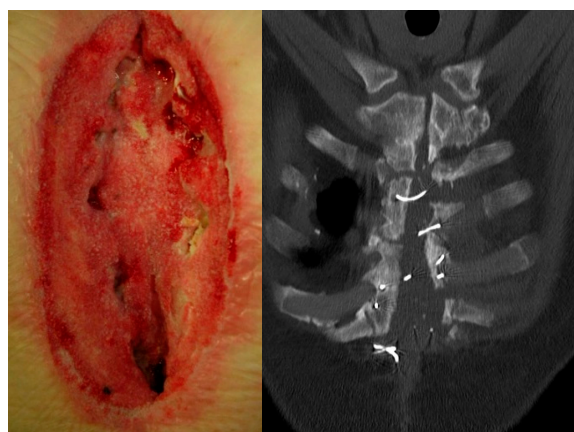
Example of grade III pathology. Poor bone substance, transverse fractures and large substance defects with wide sternal dehiscence of the sternal halves. Good granulation tissue. (Left) Intraoperative situs immediately before reconstruction. (Right) Pre-operative CT of the anterior chest wall (bone window).
